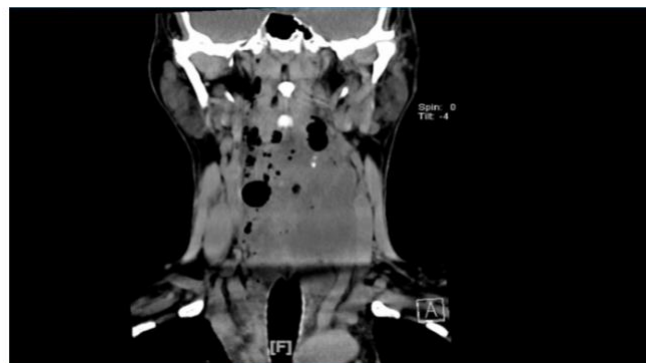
CT-Scan of the neck showed deep neck abscess
